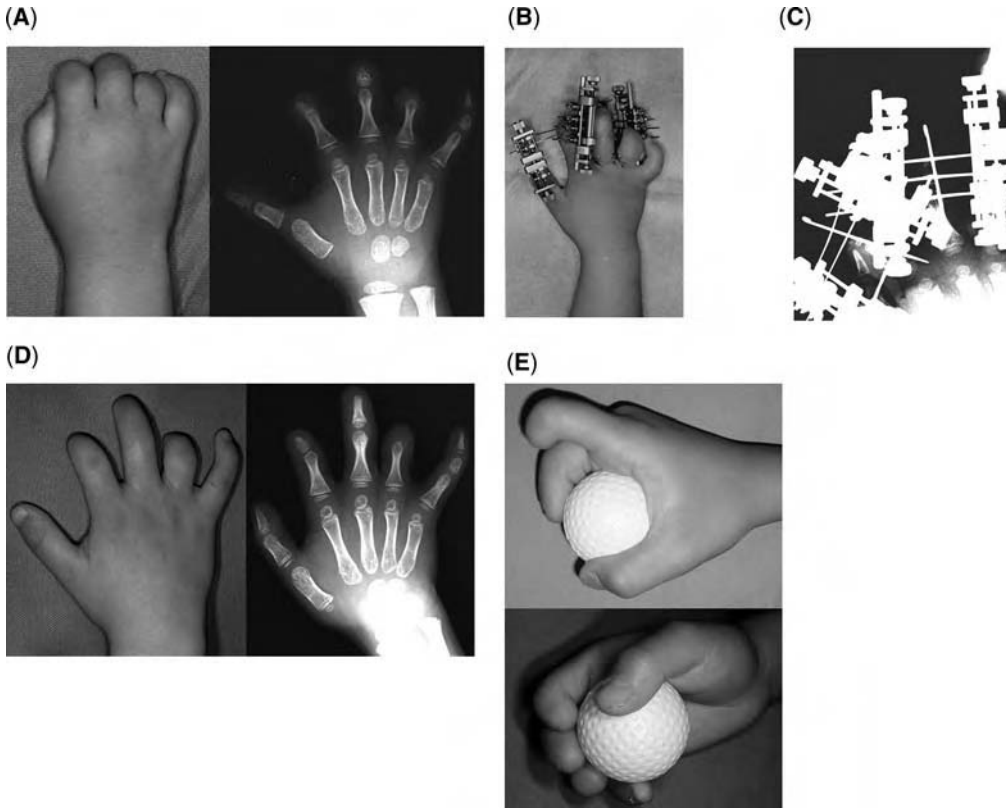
Multilateral technique for the lengthening of index and middle phalanges in a three-year-old boy with amniotic band syndrome. (A) A preoperative photograph and a radiograph of the right hand. The middle phalanges of index and middle were present but shorter than 10 mm. (B) Appearance after the operation. More care is needed handling the frames and taking care of the wound than in the monolateral method. (C) The procedure for the lengthening of the middle finger. The middle phalanx was cut center of it. A K-wire was penetrated in the distal osteomized fragment for the distal attachment, the other K-wires were penetrated in the proximal fragment of the middle phalanx and proximal phalanx for the proximal attachment. A longitudinal K-wire was inserted and fixed to prevent rotation of the distal fragment. Then the apparatuses were attached to the K-wires on bilateral sides of the middle finger. (D) The results of lengthening shown on a photograph and a radiograph. (E) The patient reported that he could grasp larger objects such as a ball and throw it, after lengthening. *Source:* From Ref. 10.
